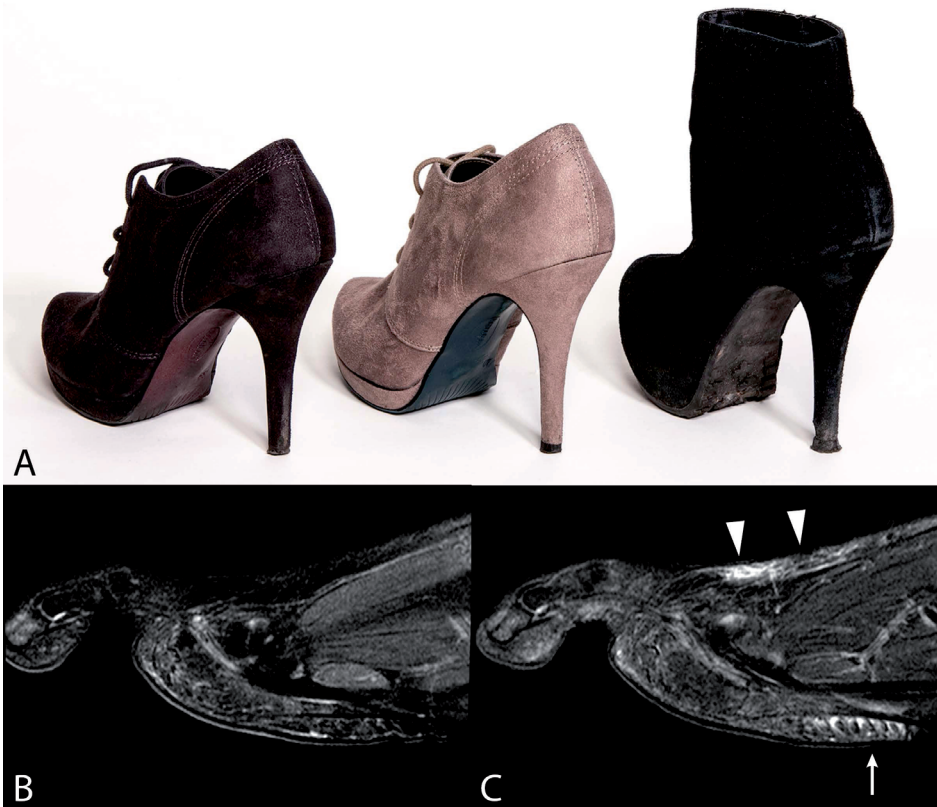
(A) High heels worn by the three subjects. (B,C) Sagittal T2-weighted fat-suppressed image at the level of the second metatarsal bone before (B) and after (C) a day of high heel wearing shows subcutaneous edema at the plantar and dorsal side. Note the proximal location to the MTP joints on the plantar side (arrow).
